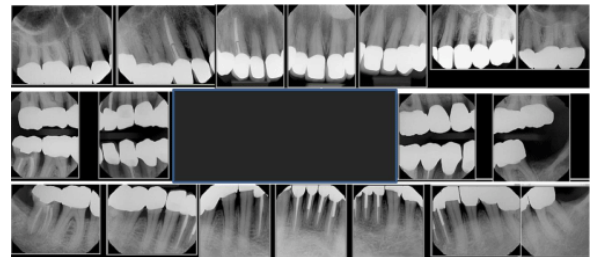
Postoperative full-mouth radiographs
